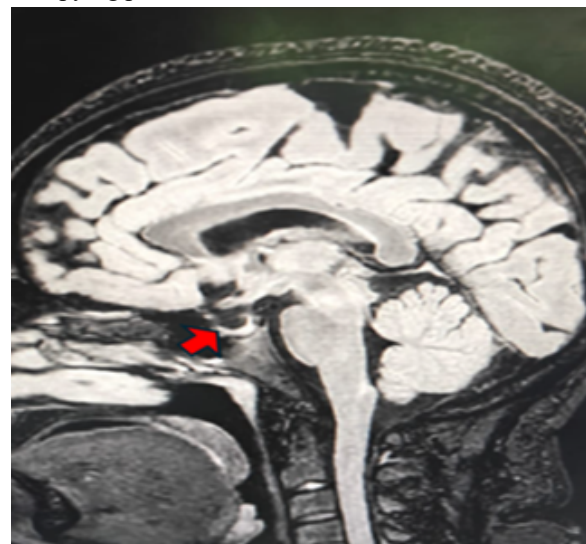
MRI Showing Partial Empty Sella
